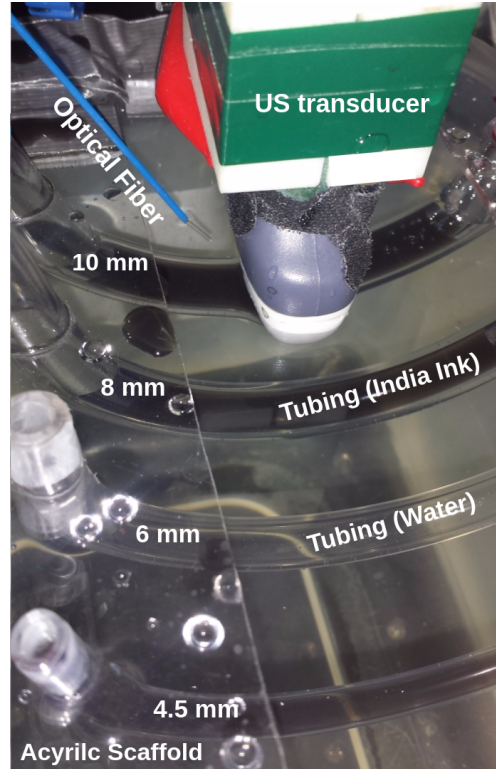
Experimental setup showing tubing of inner diameters 4.5 mm, 6 mm, 8 mm, and 10 mm (1.3 mm-, 2 mm-, and 4 mm-diameter tubing not shown) fixed in an acrylic scaffold and suspended in a water bath. The light source shown is the 1 mm-core-diameter optical fiber which was later interchanged with the 5 mm-diameter fiber bundle in the same position relative to the ultrasound transducer. An Alpinion L3-8 transducer is placed with its imaging plane viewing a circular cross-section of the tubing.
